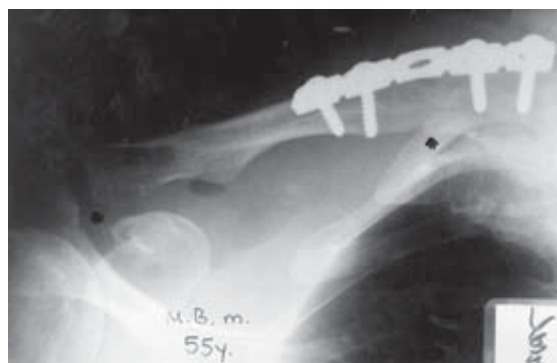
Radiographic view taken six weeks postoperatively demonstrating union of the fracture and reduction of the acromioclavicular joint.
